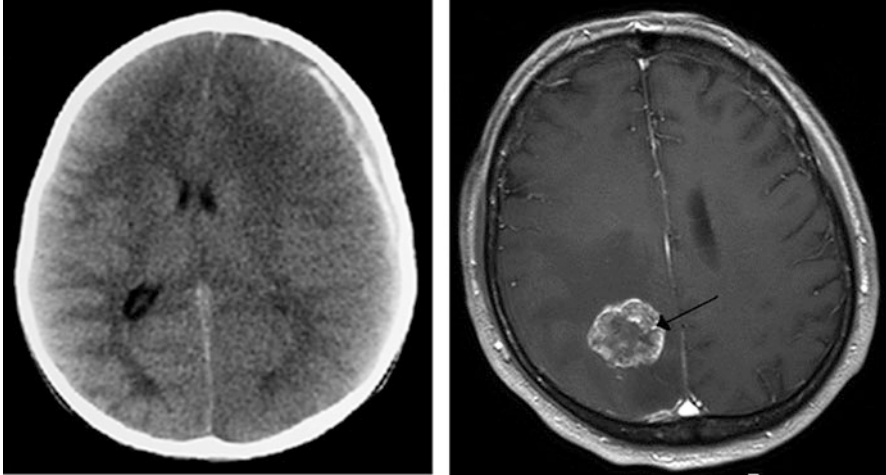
CT image of normal human brain (*left*) and human brain containing a tumor (*right*)
